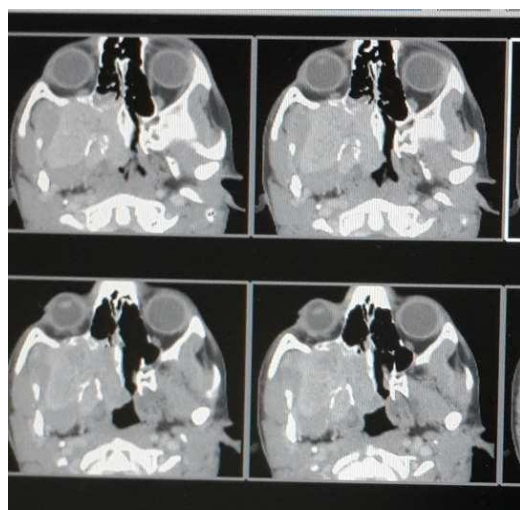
Contrast enhanced computed tomography of paranasal sinuses with 3 mm cuts.
